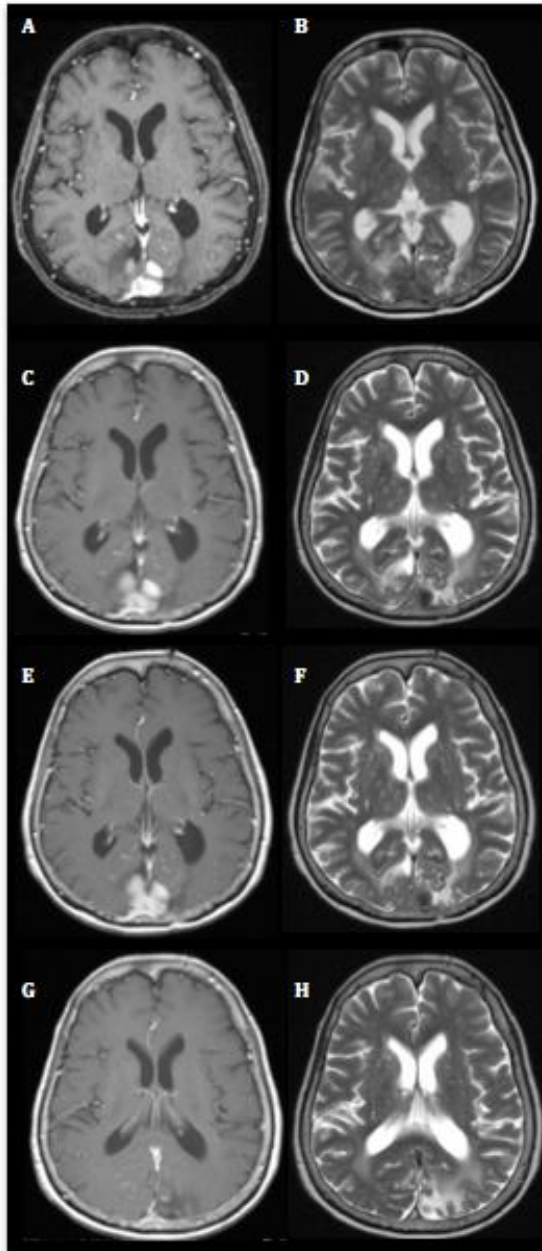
Serial MRI after the treatment period. A. Initial Axial T1-weighted imaging with contrast and B. T2-weighted imaging 4 months after treatment. C. Axial T1-weighted imaging with contrast and D. T2-weighted imaging after 8 months. E. Axial T1-weighted imaging with contrast and F. T2-weighted imaging after 13 months. G. Axial T1-weighted imaging with contrast and H. T2-weighted imaging after 16 months of treatment
